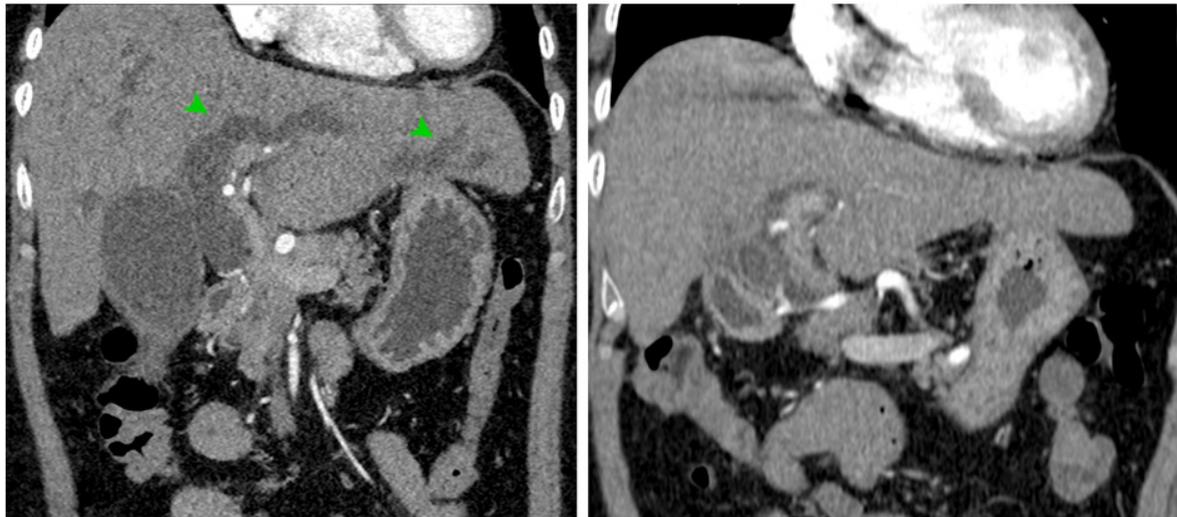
Left: CT-Scan of the abdomen at diagnosis, showing dilatation of intrahepatic bile duct (green arrow). Right: CT-Scan performed 1-month post chemotherapy, showing no sign of bile duct dilatation.
